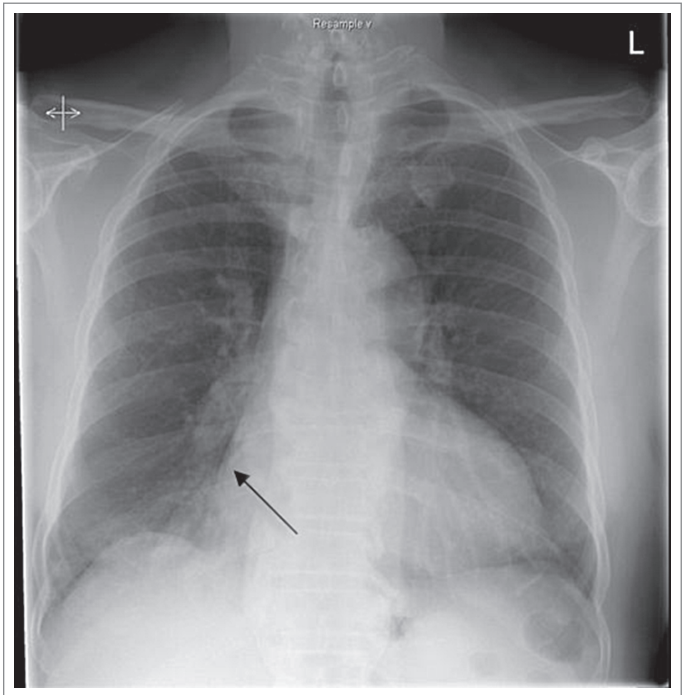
Admission PA chest X-ray. The chicken bone is visible as an opacity at the right heart border (arrow).
